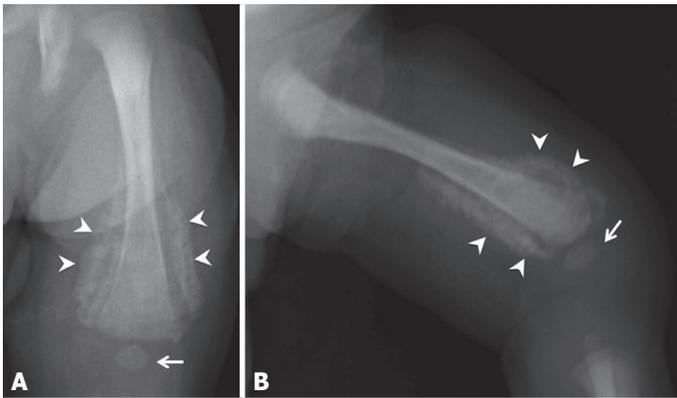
Radiograph of the left femur and knee demonstrates periosteal reaction (arrowheads) and soft tissue swelling at the left distal femur. Slight posterior displacement of the femoral epiphyseal ossification center is seen (arrow). No fracture line is identified.
